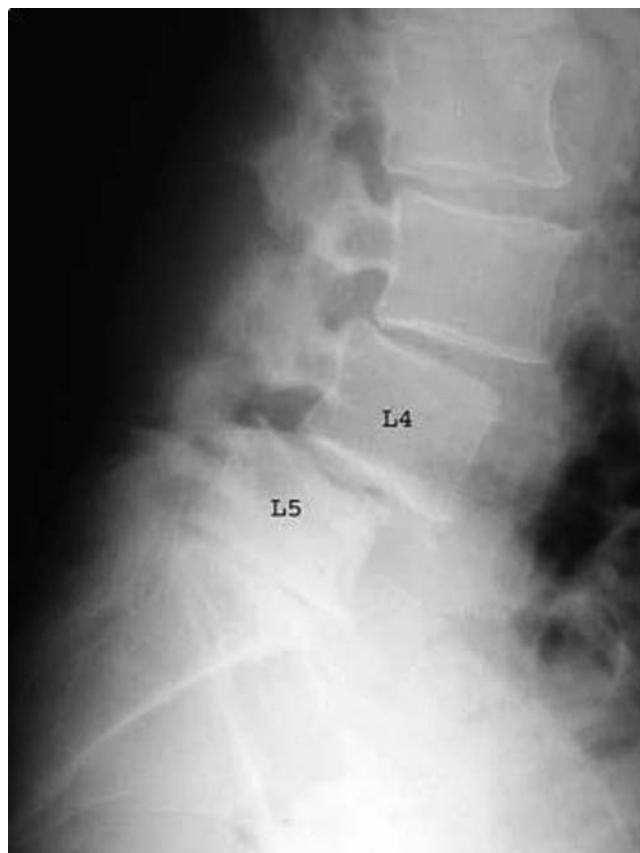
Lateral lumbar spine X-ray demonstrates a 25% anterior slippage of L4 on L5 due to a defect in the L4 pars interarticularis. This is called *spondylolisthesis*.
